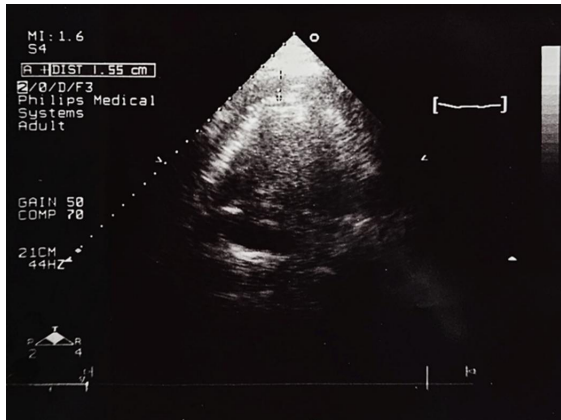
Echocardiographic image demonstrating pericardial effusion surrounding the heart, measuring 1.55 cm.
